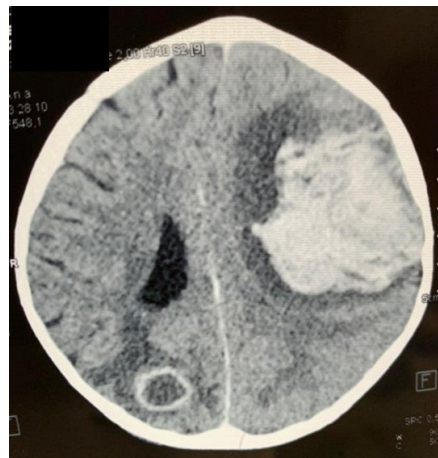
Contrast head CT scan with brain abscess and intraparenchymal hematoma.
